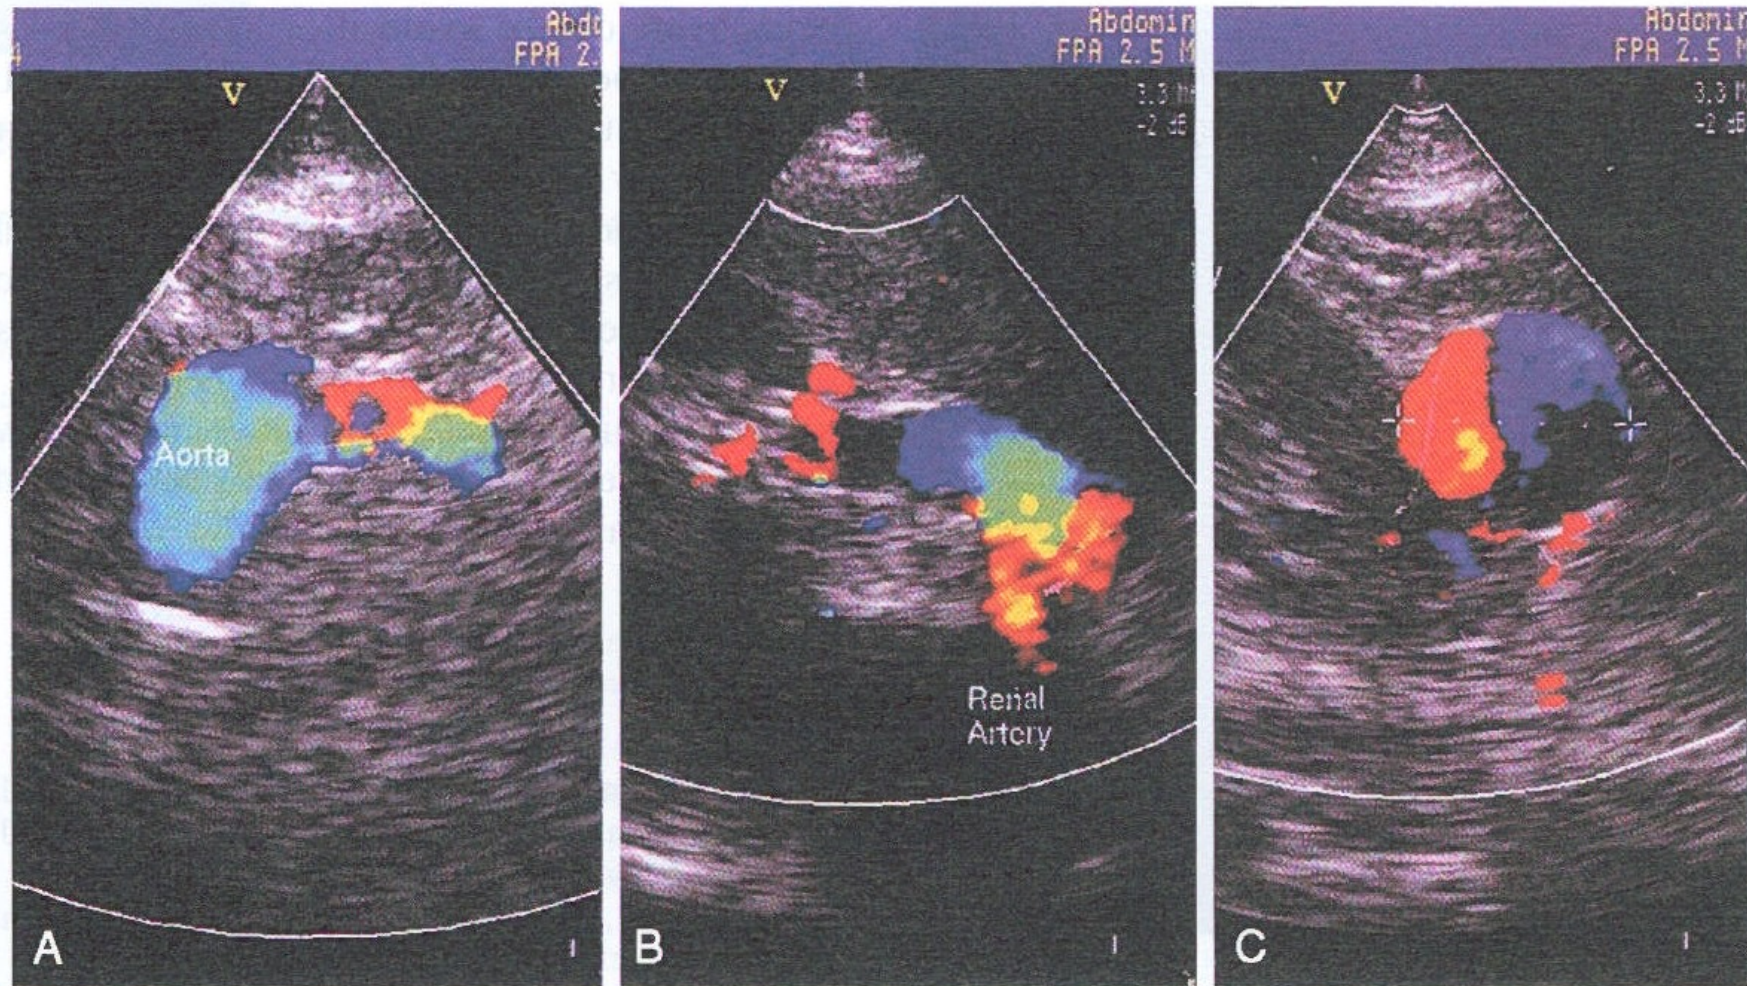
A–C. Colour ultrasonography examination shows the dilated, tortuous left renal artery. A large aneurysm, partially exophytic, can be seen at the lower pole of the kidney. There is coexistence of both arterial and venous blood flow.
